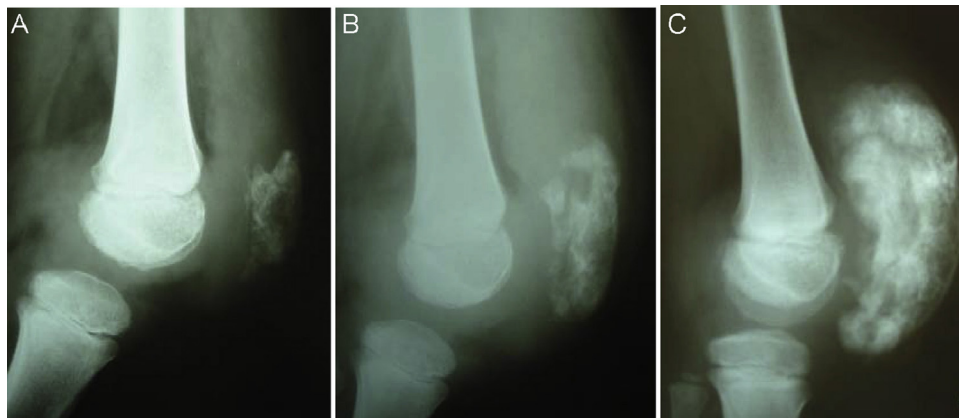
Preoperative appearance on lateral radiographs of the right knee, with patellar tumor formation showing one month of evolution (A), one year (B) and immediately before the surgery (C): hemimelic epiphyseal dysplasia.
